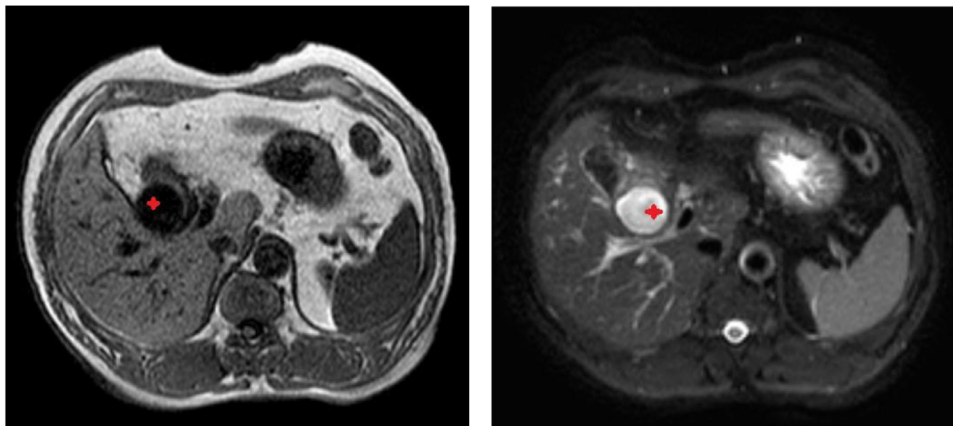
Magnetic resonance imaging (MRI) showing the pseudoaneurysm (red pointer) as hypointense lesion on T1 sequence and hyperintense lesion on T2 sequence.
